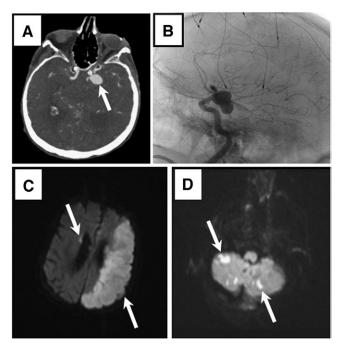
Preprocedure imaging. A, Postcontrast computed tomography angiography (CTA) of the brain source image shows laterally projecting enhanced saccular aneurysm in the left supraclinoid internal carotid artery (ICA) (arrow), and (B) conventional cerebral angiogram (lateral projection of selective left internal carotid artery angiogram) shows the bilobed aneurysm, projecting posteriorly from the communicating segment of the left supraclinoid carotid artery (the left posterior communicating artery is patent). Post-procedure imaging. Diffusion-weighted images from noncontrast MRI of the brain (postprocedure day 2) demonstrate foci of acute infarcts, with associated diffusion restriction, involving (C) a large portion of the left MCA territory and right caudate nucleus, and (D) the bilateral cerebellar hemispheres (arrows).
